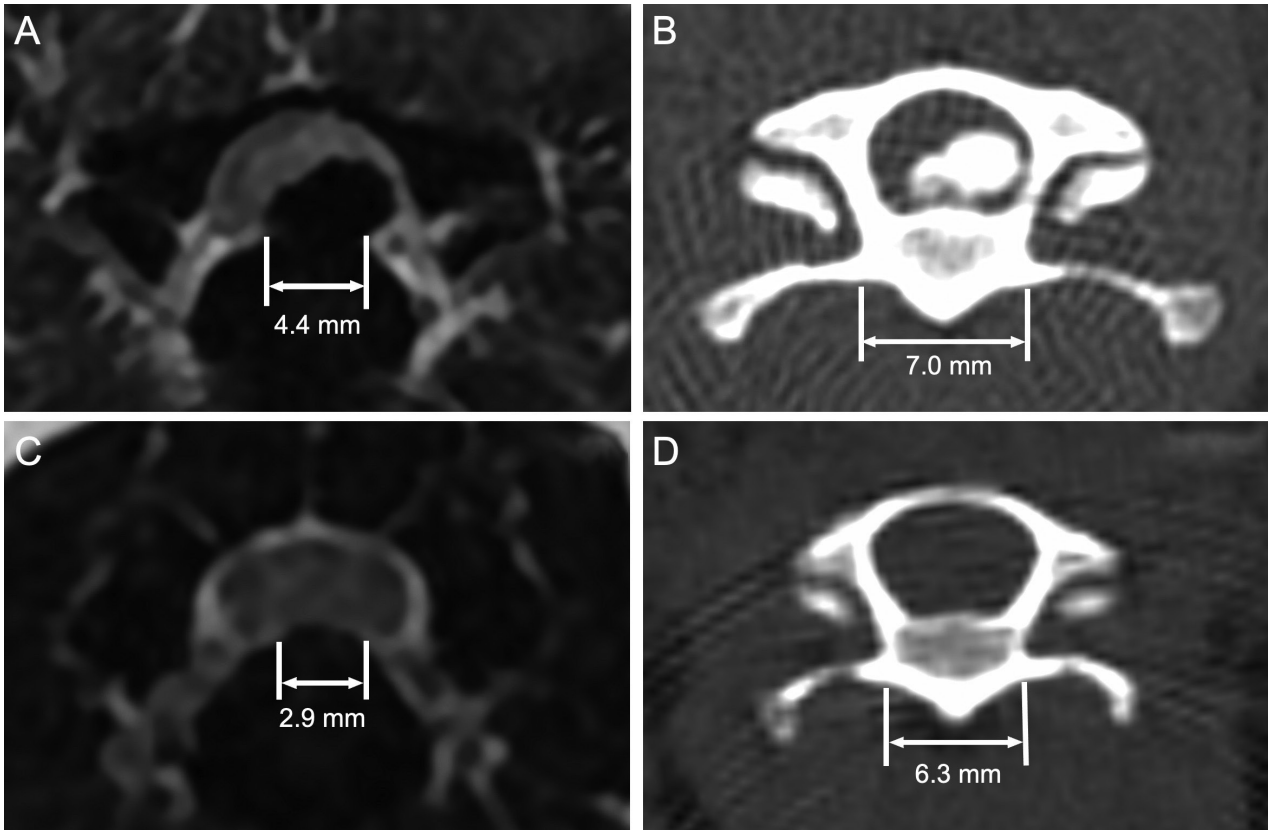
Example of slot width measurement method using MRI images and vertebral width measurement method using CT images. Transverse T2-weighted MRI images of the cervical spine obtained before contrast administration (A) and CT images (B) in a 5-year-old 4.2-kg Pekingese with disc extrusion. Transverse T2-weighted MRI images of the cervical spine obtained before contrast administration (C) and CT images (D) in a 10-year-old 3.2-kg Yorkshire Terrier with disc protrusion. The transverse width (= slot width) of the herniated disc material in the Pekingese was 4.4 mm and the vertebral width was 7.0 mm, and vertebral fixation (VF) was combined because the slot width was 62.8% (> 33.3%) of the vertebral width. The transverse width (= slot width) of the herniation protrusions in the Yorkshire Terrier was 2.9 mm and the vertebral width was 6.3 mm, and VF was combined because the slot width was 46.0% (> 33.3%) of the vertebral width.
